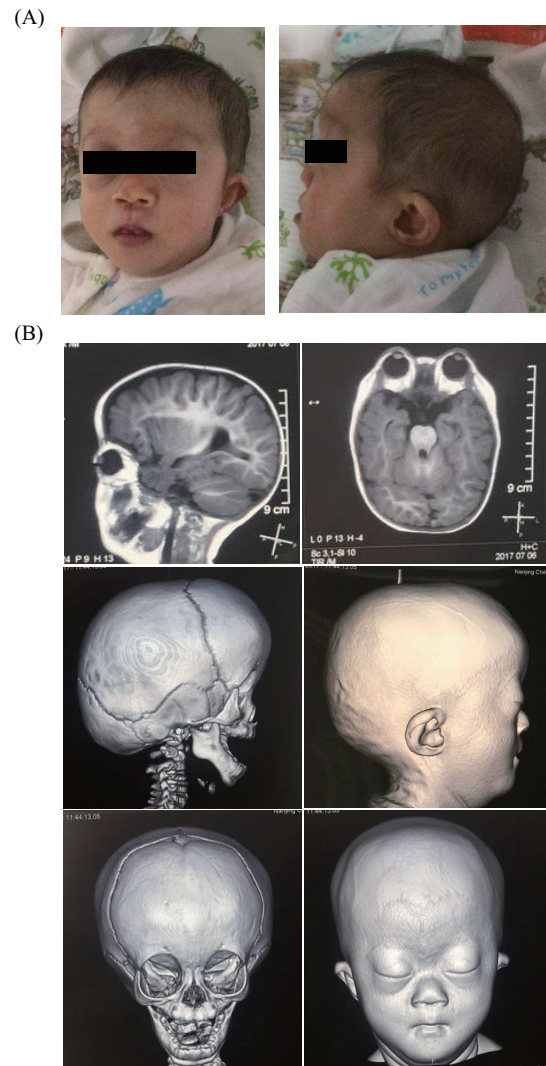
Skeletal abnormalities of head and face. A, Facial characteristics at age of 8 months. B, MRI of the skull revealed premature fusion of the skull bones (craniosynostosis), a flattened mid-face, frontal bossing, broad forehead and low-set ears.
